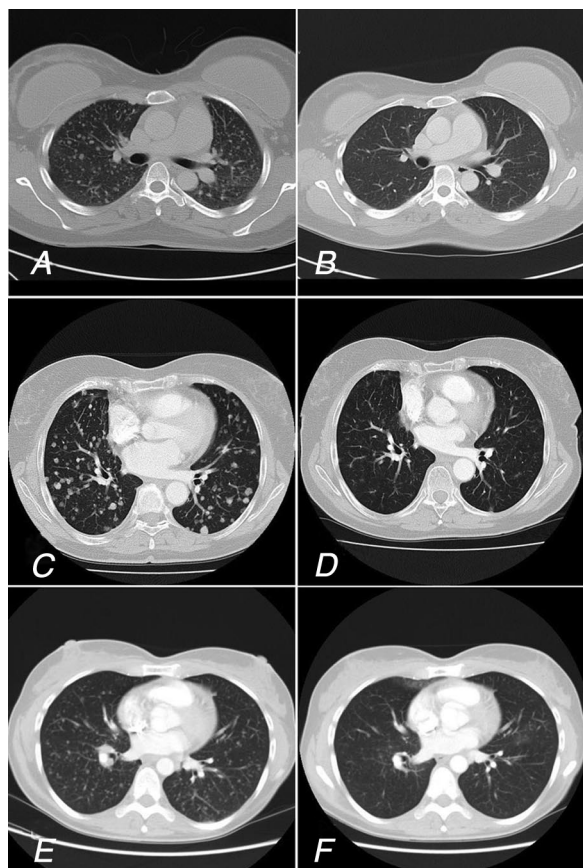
Transverse computed tomography (CT) images (window center/window width: 450/1800 Hounsfield units) represents the three patients before treatment (A: case 1, C: case 2, and E: case 3) and horizontally corresponding images of the same patients (B: 7 weeks later, D: 8 weeks later, and F: 17 weeks later) after treatment with EGFR tyrosine kinase inhibitor erlotinib. The right column of images demonstrates a clearly visible reduction of metastasis in size and number.
